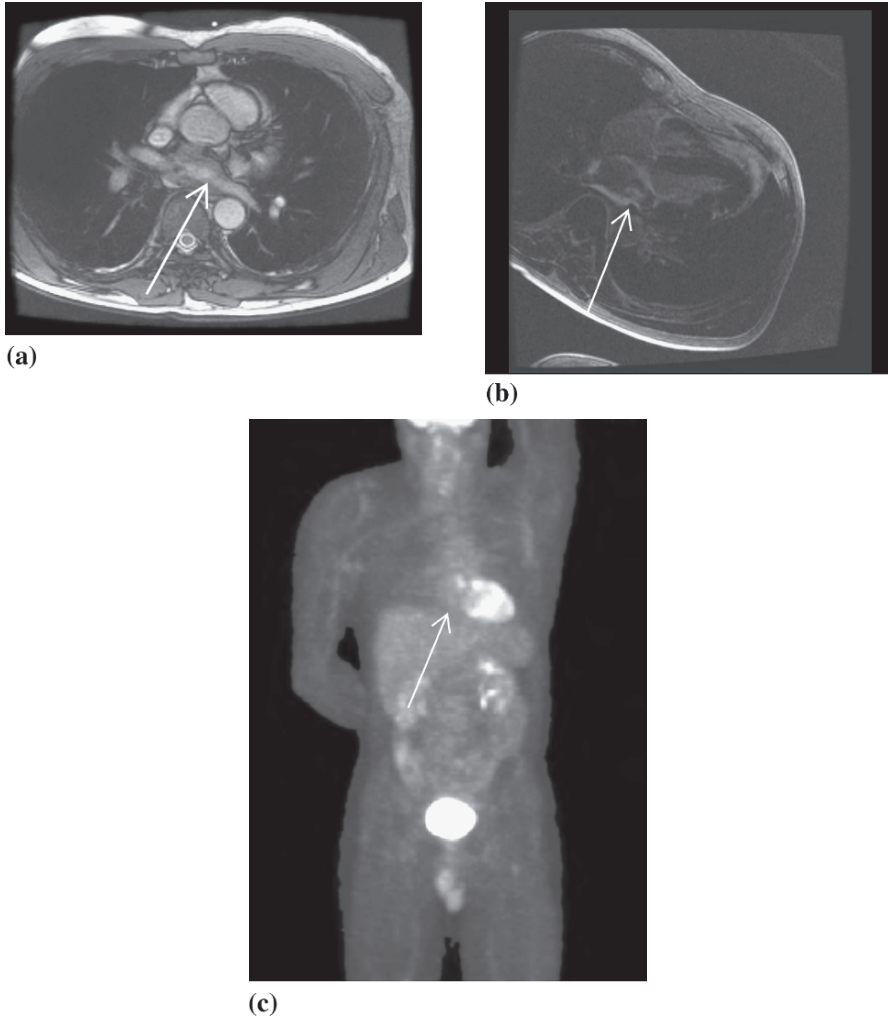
47-year-old man with pathologically proven spindle cell sarcoma of the left atrium. T2- (2a) and post-contrast T1- (2b) weighted MR images show an ill-defined infiltrating mass in the superior portion of the left atrium involving the ostium of left superior pulmonary vein (arrow). A three-dimensional projection PET image (2c) shows an area of increased glucose uptake in the area corresponding to left atrium (arrow). (Note: the left ventricle shows variable uptake under normal circumstances). (Ao, aorta; LA, left atrium; RVOT, right ventricle outflow tract)
